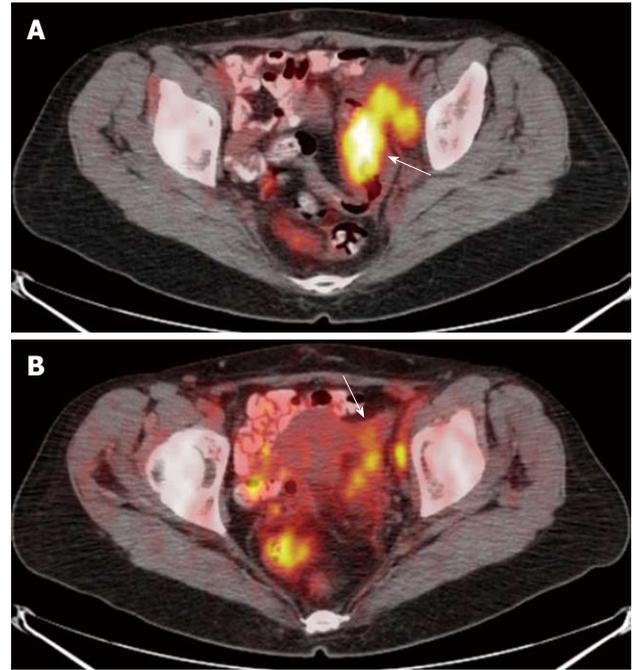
The fused positron emission tomography/computed tomography images show a neoplastic lesion of the sigmoid colon concentrating the radio-tracer (arrow) (SUVmax 14.6) (A) and focal radio-tracer uptake of the left ovary (arrow) (SUVmax 9) (B): the finding was suggestive of ovarian infiltration. The lesion was correctly classified as T4.
